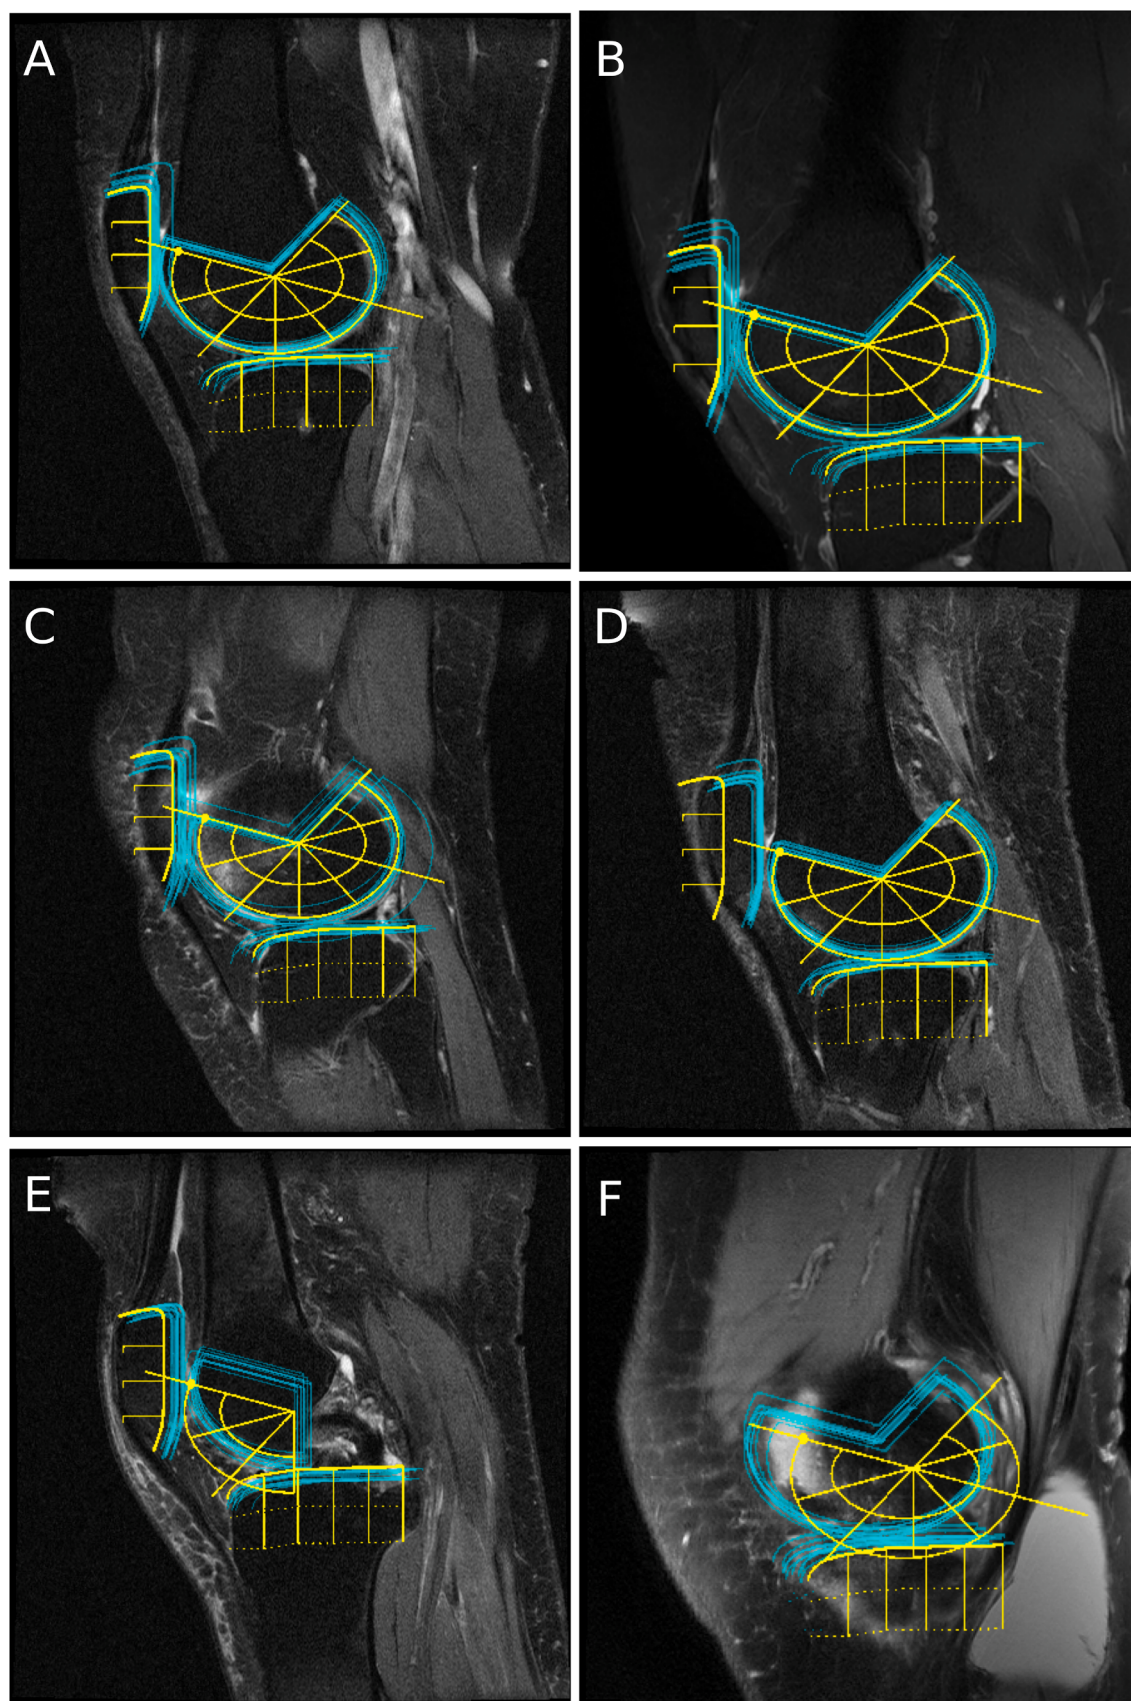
A hand-selected sample of slices from the 40 MRI cases used in the study with overlays depicting the 11 readers' manual grid placements (cyan; internal grid lines have been removed for clarity) and iKIMRISS' automatic grid placement (yellow). Panes A–C depict examples of good automated grid positioning relative to manual consensus, while panes D–F exemplify three common grid mispositioning errors observed throughout the dataset: patella misidentification (D), intercondylar femur mispositioning (E), and grid misplacement at the medial femoral epicondyle (F).
